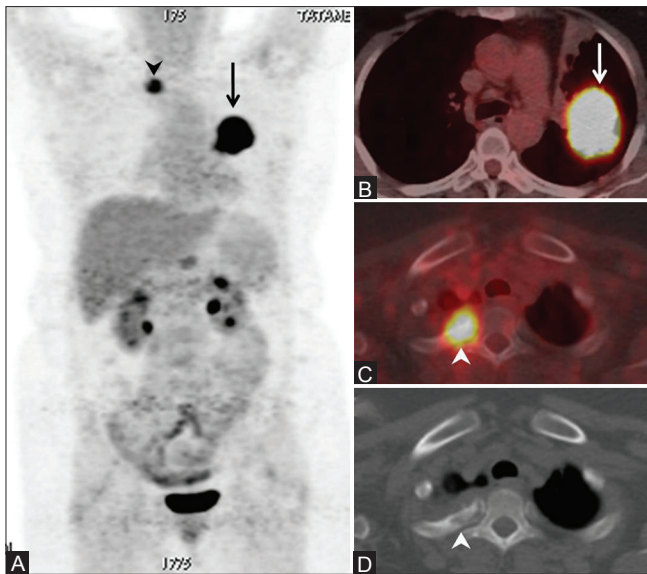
(A-D): Asymptomatic marrow metastases detected on FDG PET/CT. MIP image of an FDG PET scan of a lung cancer patient shows intense tracer concentration in a mass lesion in the left hemithorax (arrows in A and B) and another smaller lesion in the right hemithorax (arrowhead, B). Intense tracer concentration is seen on FDG PET/CT in the right second rib suggesting metastatic disease (arrowhead, C). Note the subtle marrow changes in the rib on CT scan (arrowhead, D)
